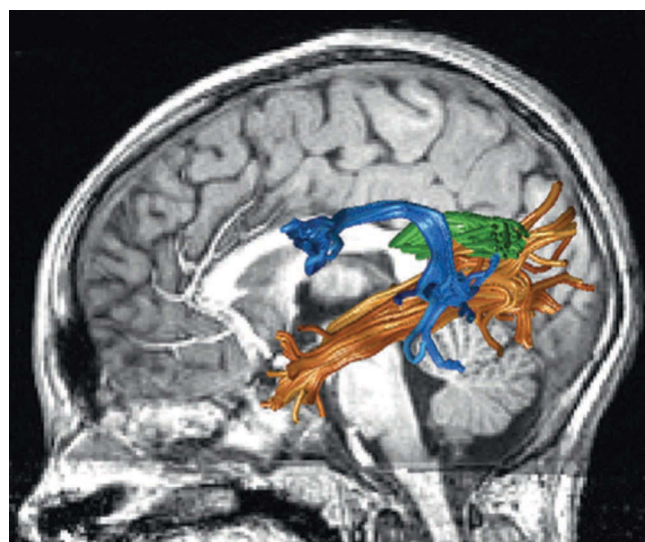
Reading circuitry. Diffusion magnetic resonance images were acquired in living human brains. The diffusion images, combined with fiber tractography, were used to identify several of the fiber bundles comprising the circuitry for reading: arcuate fasciculus (blue), inferior longitudinal fasciculus (orange), and temporal callosal projections (green) for a representative subject. The underlay is a sagittal slice from a T1-weighted image of the same subject. For the software and data used to create this image, see http://github.com/jyeatman/reading_circuits. (Reproduced from Wandell, B.A. and Yeatman, J.D., *Curr. Opin. Neurobiol.*, 23, 261, 2013.)
